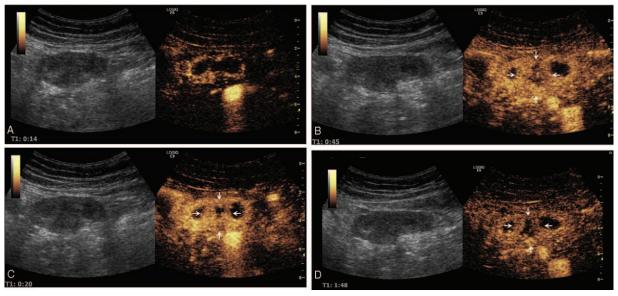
Contrast-enhanced ultrasound images evaluating the lesion at 14 seconds, 20 seconds, 45 seconds, and 1 minute past 48 seconds are shown in the figures of A, B, C, and D, respectively. The heterogeneous lesion (arrowhead) displays mildly delayed and inhomogeneous enhancement compared with the normal appendiceal wall. The central part of the lesion largely shows low enhancement except for little non-enhancement and this low-enhanced area gets larger and larger gradually after 30 seconds. It is diagnosed as cystadenoma of the appendix other than Purulent appendicitis by CEUS. CEUS=contrast-enhanced ultrasound.
